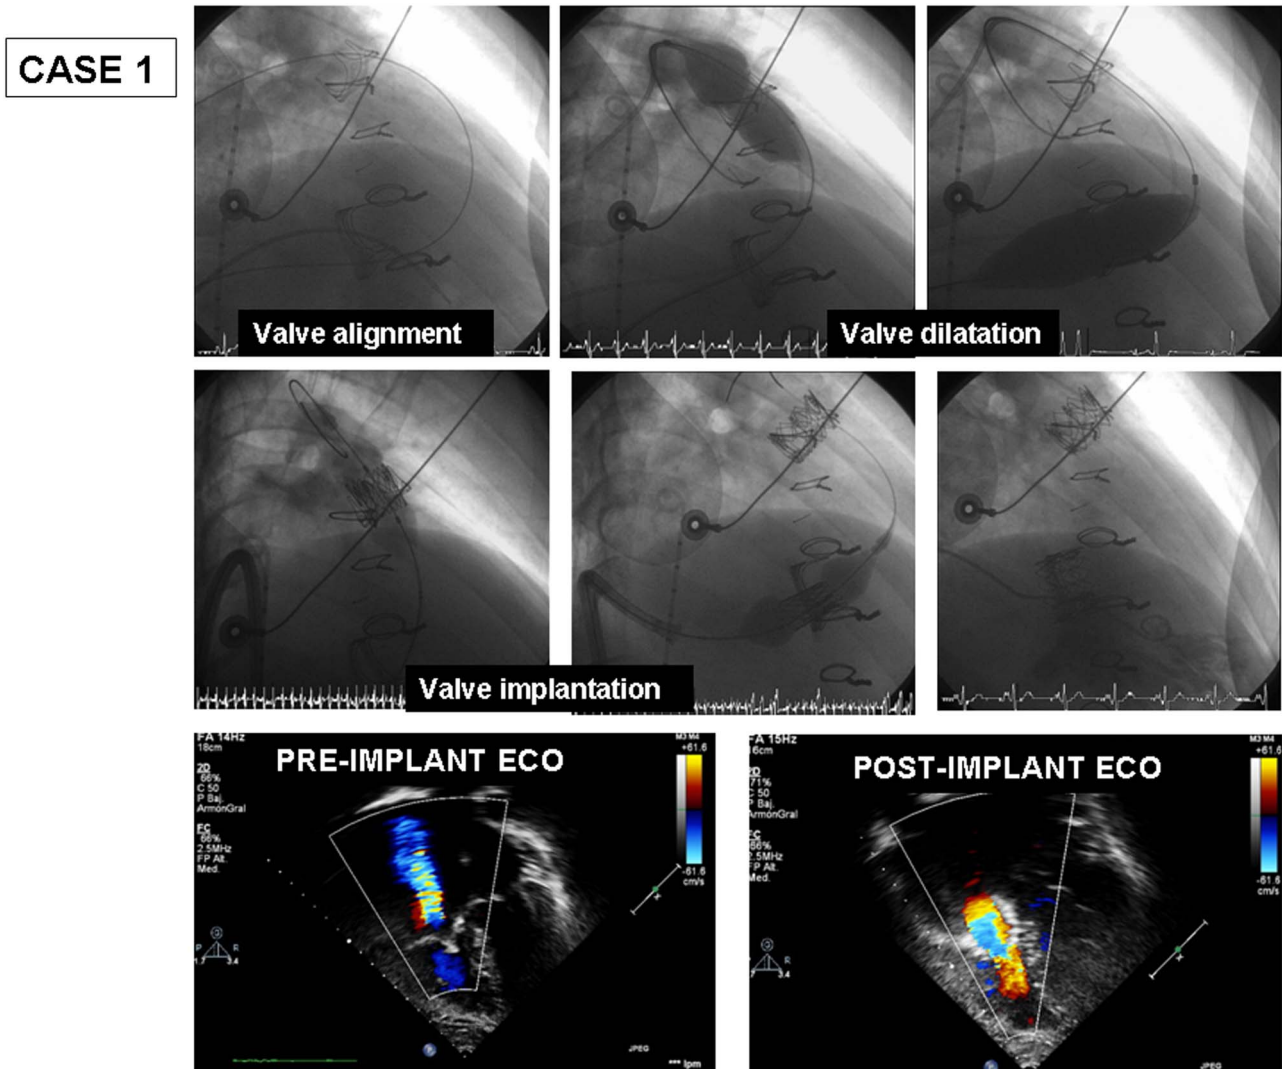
Valve implantation steps during catheterization. Echocardiography pre and post valve implantation.
